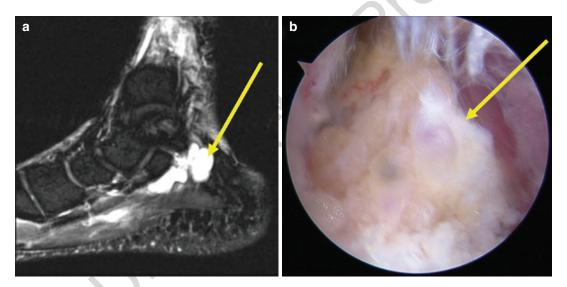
(a) MRI showing cyst with fluid causing impingement (yellow arrow); (b) arthroscopic view of the same cyst (yellow arrow) causing soft-tissue impingement
